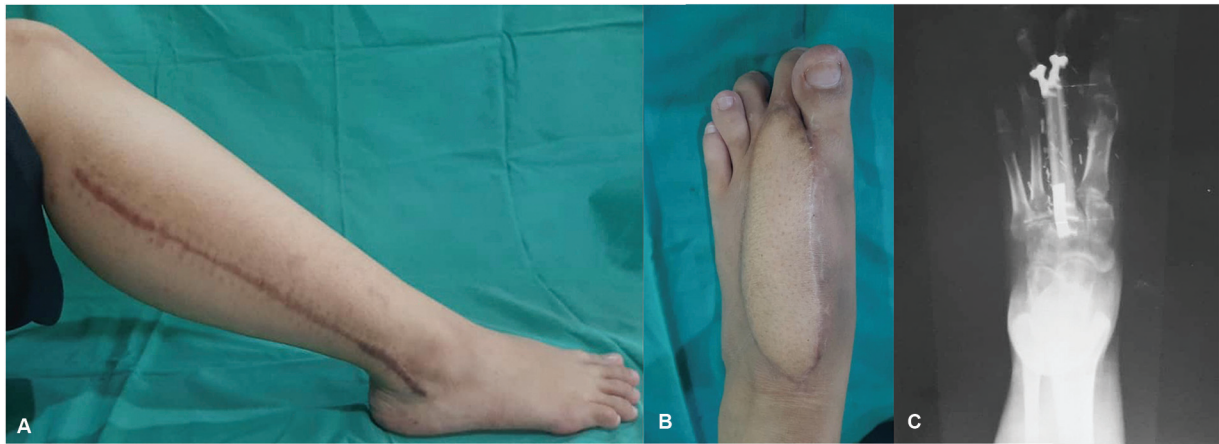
Right leg (donor site) and left foot (recipient site) appearance after 6 months. The observations as shown by clinical and radiological examinations. (A) The donor site healed well with no obvious skin changes suggestive of ischemic limb. (B) The flap appearance after 6 months. (C) Left foot's X-ray showing minimal hypertrophy with no resorption suggesting graft viability.
